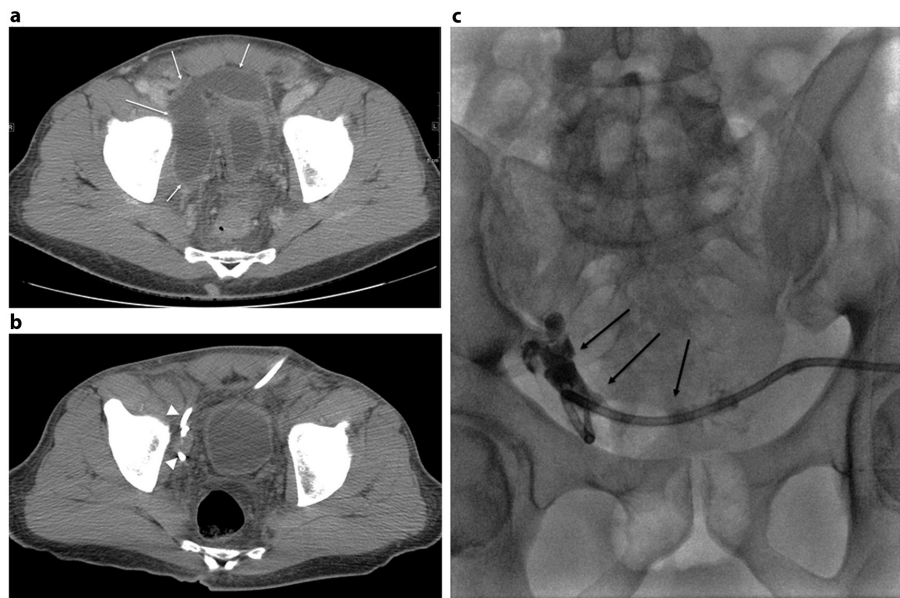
A 57-year-old male with a history of robotic prostatectomy and pelvic lymphadenectomy presenting with pelvic pain. (a) Computed tomography of the abdomen and pelvis showing right pelvic fluid collection (white arrows). (b) Collection completely drained with a 10.5 Fr drainage catheter (white arrow heads), but a consistently high output of 195 cc/day was noted for the following 2 weeks. (c) The residual cavity filled with 12 cc of contrast with no evidence of communication with the surrounding structures (black arrows). A total of 12 cc of 3% sodium tetradecyl sulphate (STS) mixture (2 mL STS, 8 mL iodinated water-soluble contrast, 2 mL air) was subsequently injected (not shown) and allowed to dwell for 2 hours. Output subsequently dropped to 5 cc/day, and the drain was removed after 7 days.
